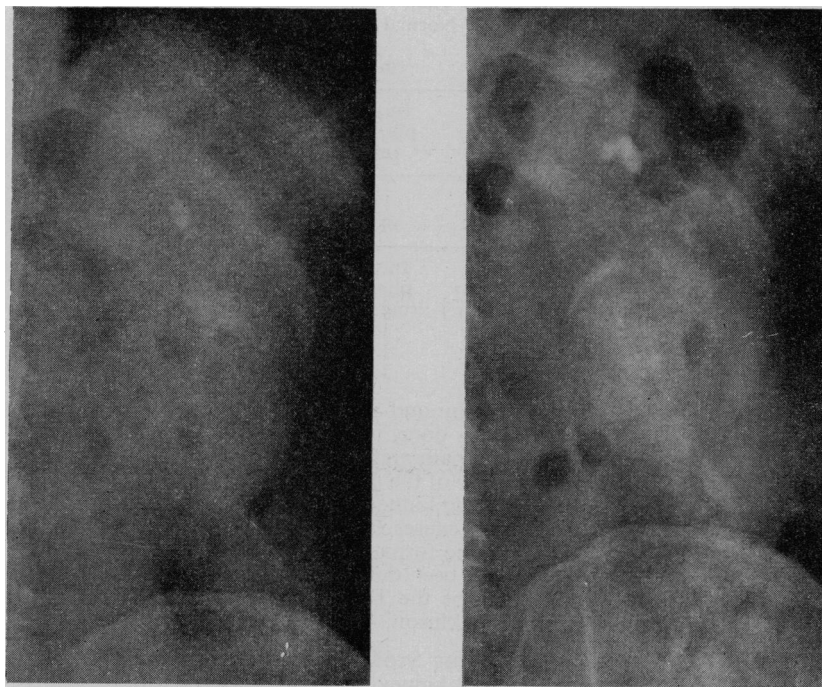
Straight X-ray and intravenous pyelogram of male patient, W. S. I., aged 56, showing a stone in the upper major calyx of the left kidney.
